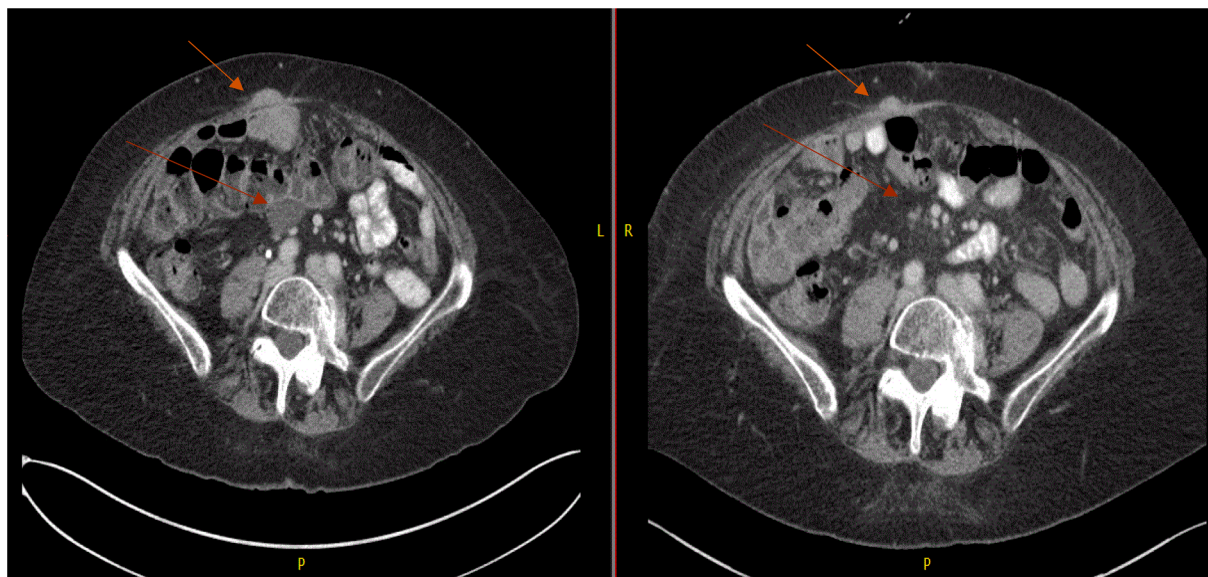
CT scans before and 9 weeks after initiating therapy.
